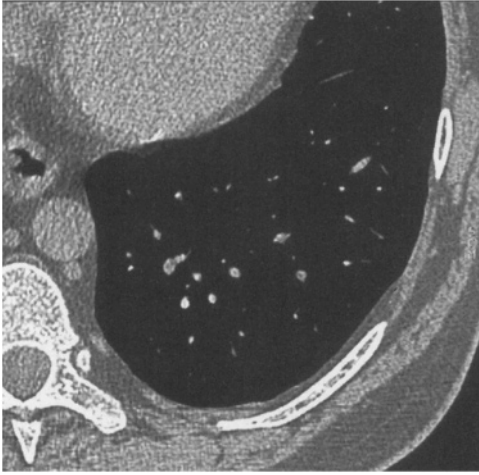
CT scan : subpleural fat deposit
